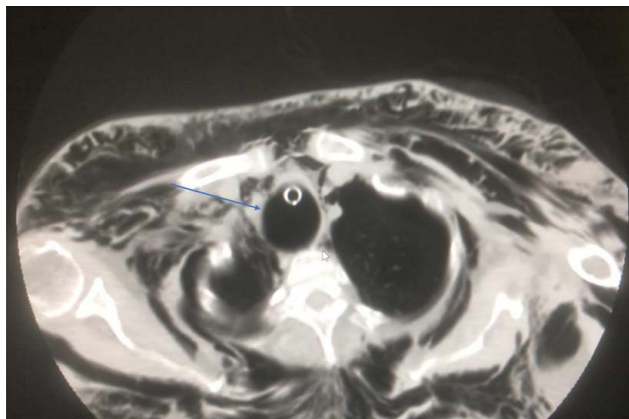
Thoracic computed tomography reveals dilation of the trachea.
